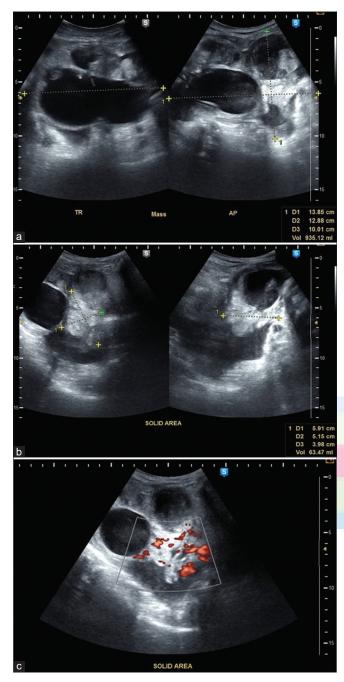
Transvaginal and transabdominal ultrasound results showing (a) abdominopelvic mass, (b) solid area of mass, and (c) color flow mapping showing moderate peripheral flow with intratumoral flow to solid areas
